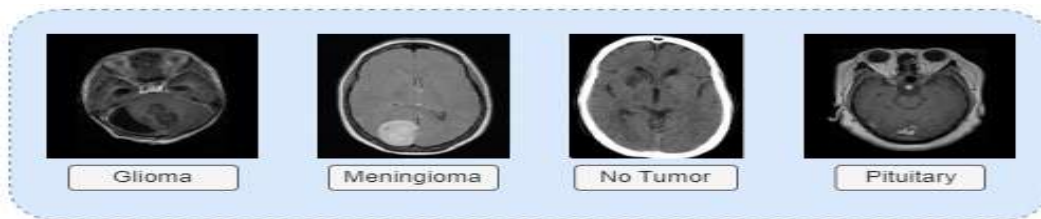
Brain Tumour MRI dataset with four classes
